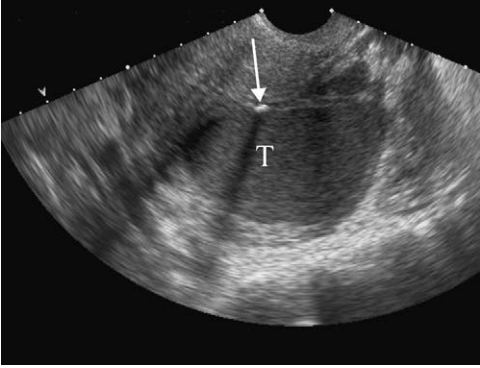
Tubal Endometrioma. Ultrasound shows the classic “ground glass” appearance in an endometrioma (T). A mural reflector (arrow) is seen within the cyst wall. This is a highly specific sign for an endometrioma.
